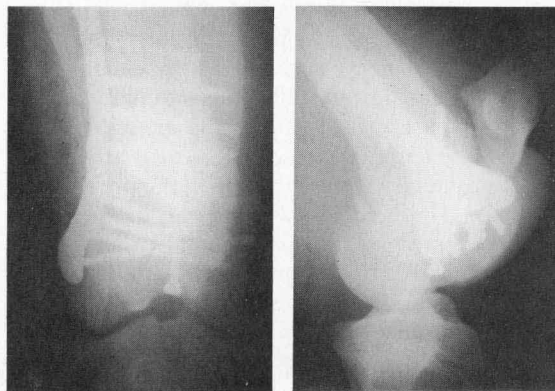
Caudocranial [left] and lateromedial [right] radiographic views immediately after surgery. The condylar buttress plate was placed laterally. Notice a long cortical screw placed through the distal portion of the femur and directed proximally into the metaphyseal and diaphyseal regions.
